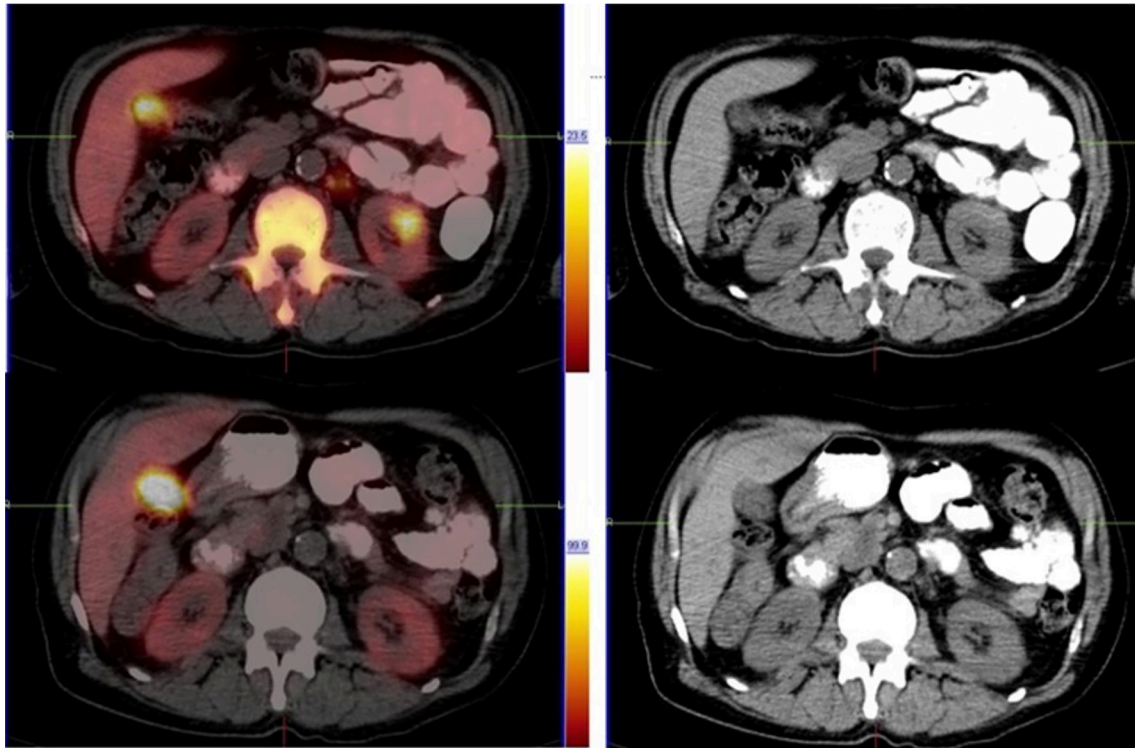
^{18}F PET/CT and CT only images of the same patient. The images in the top row reveal increased PSMA expression in the left kidney (SUV: 24.7), with no obvious CT changes. The images below are after 4 cycles of ^{177}Lu -PSMA radioligand therapy, which demonstrate complete resolution of the disease in the left kidney (SUV: 6.5). Few cases of prostate cancer metastasizing to the kidney have been reported (4,5,6). Chen et al. (6) described renal metastases in the setting of prostate cancer as an extremely rare entity.
